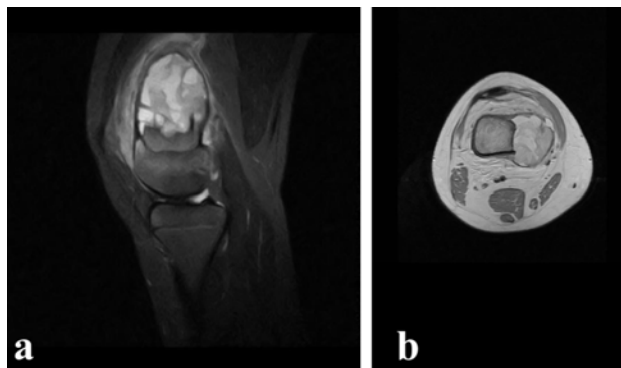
Aneurysmal bone cyst of the distal femur. (a) sagittal T2-weighted MRI and (b) axial T1-weighted MRI showing characteristic multiple fluid levels.
